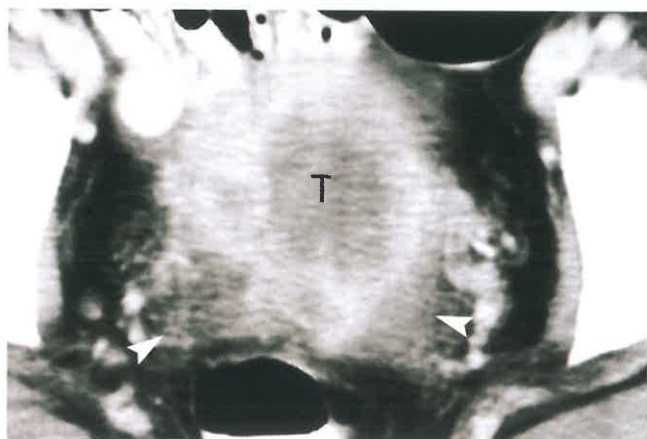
Cervical Carcinoma—CT. Heterogeneous tumor (T) has completely replaced the cervix on this CT scan. Stranding densities (arrowheads) into the paracervical fat indicate parametrial invasion by tumor.
